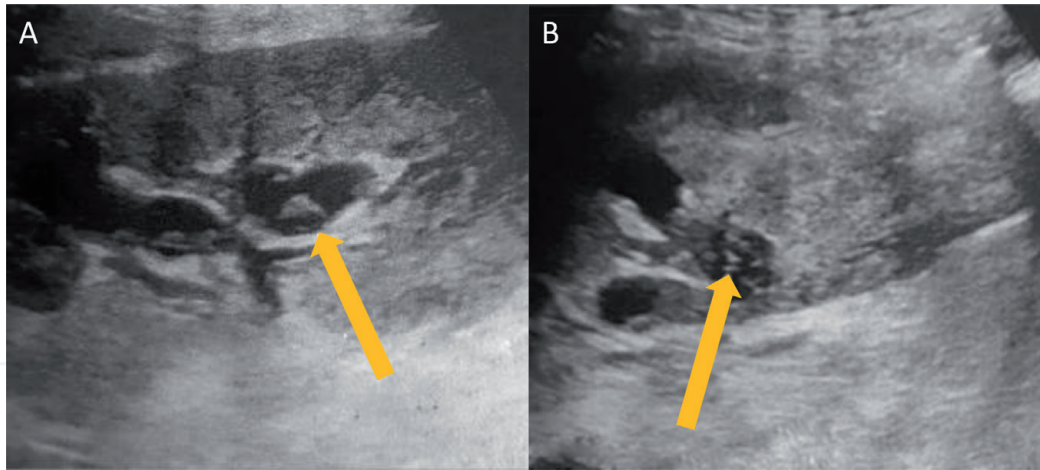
Exploratory ultrasound performed on patient with gross hematuria, 24 hours after percutaneous native kidney biopsy. (A and B) Multiple pelvic blood clots (arrow) after renal biopsy.
